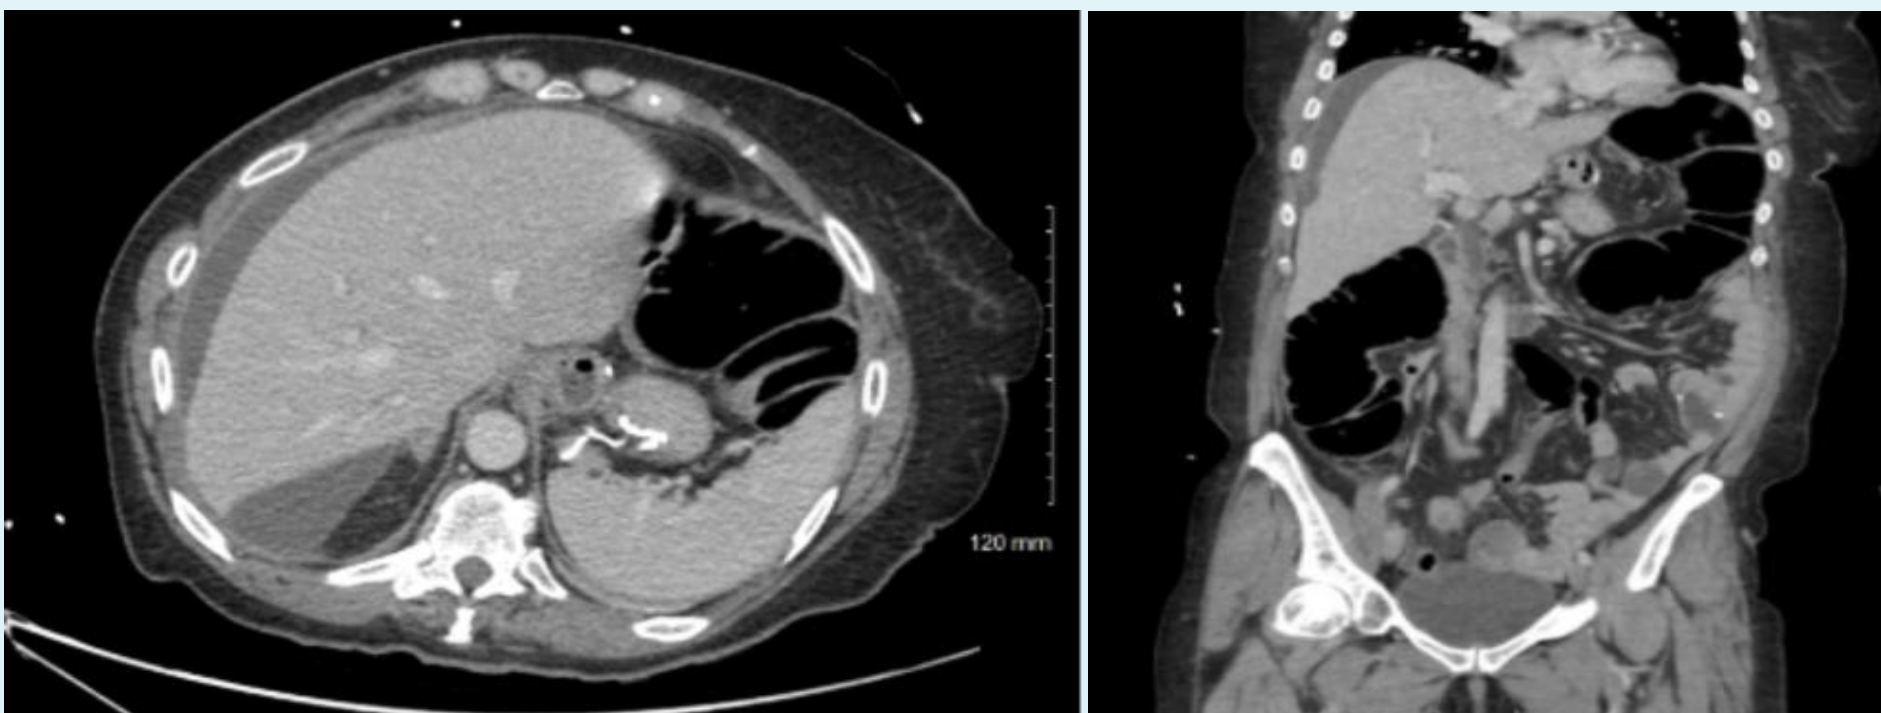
CT scan of the abdomen showing subhepatic fluid.
